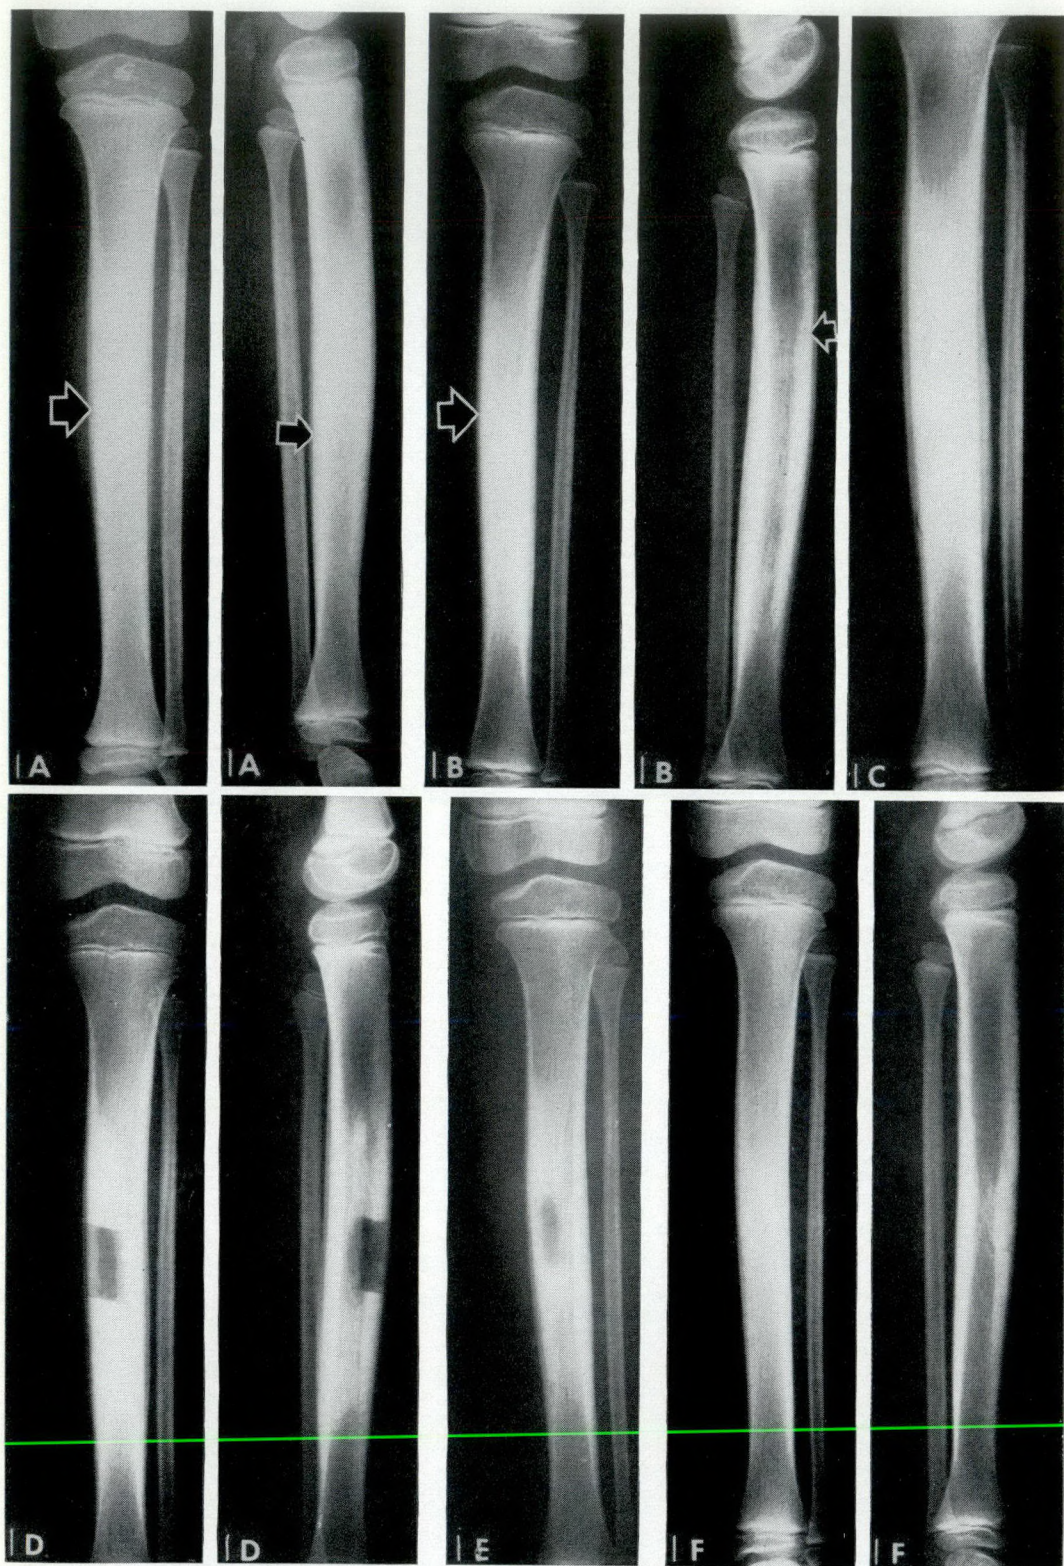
Left leg: Serial radiographs demonstrating (a) (b) and (c) the progression of the disease process; (d) the site of biopsy; (e) and (f) the subsequent gradual regression of the disease process (see text for clinical details).
